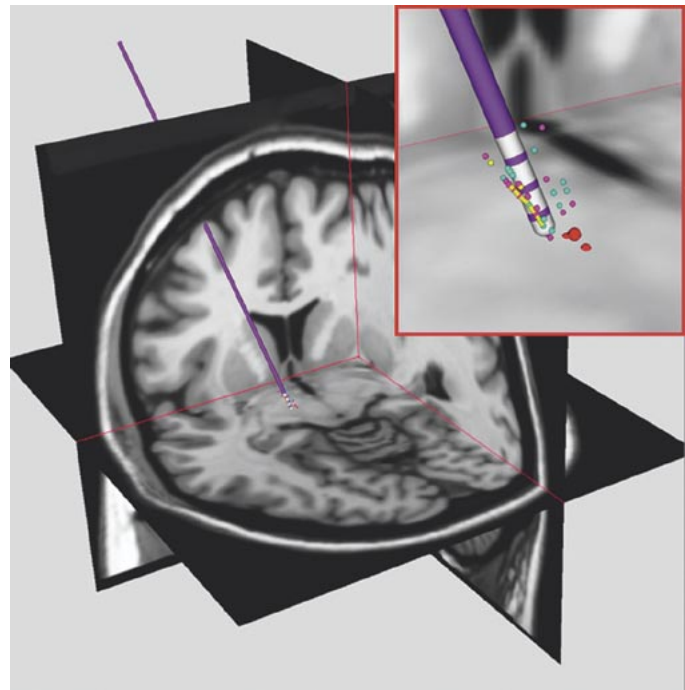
Reference brain MRI and modeled quadripolar deep brain stimulator with tip inserted into left subthalamic nucleus. Inset: Results of a search for functional data characteristic of those acquired during STN procedures. Yellow spheres: tremor cells. Magenta spheres: cells with firing patterns characteristic of STN neurons (with no obvious receptive field). Cyan spheres: neurons with kinesthetic activity. Red spheres: stimulation induced paresthetic responses.
